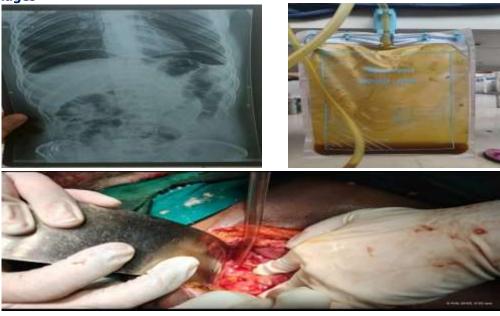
Erect X-ray abdomen of patient with perforation.
